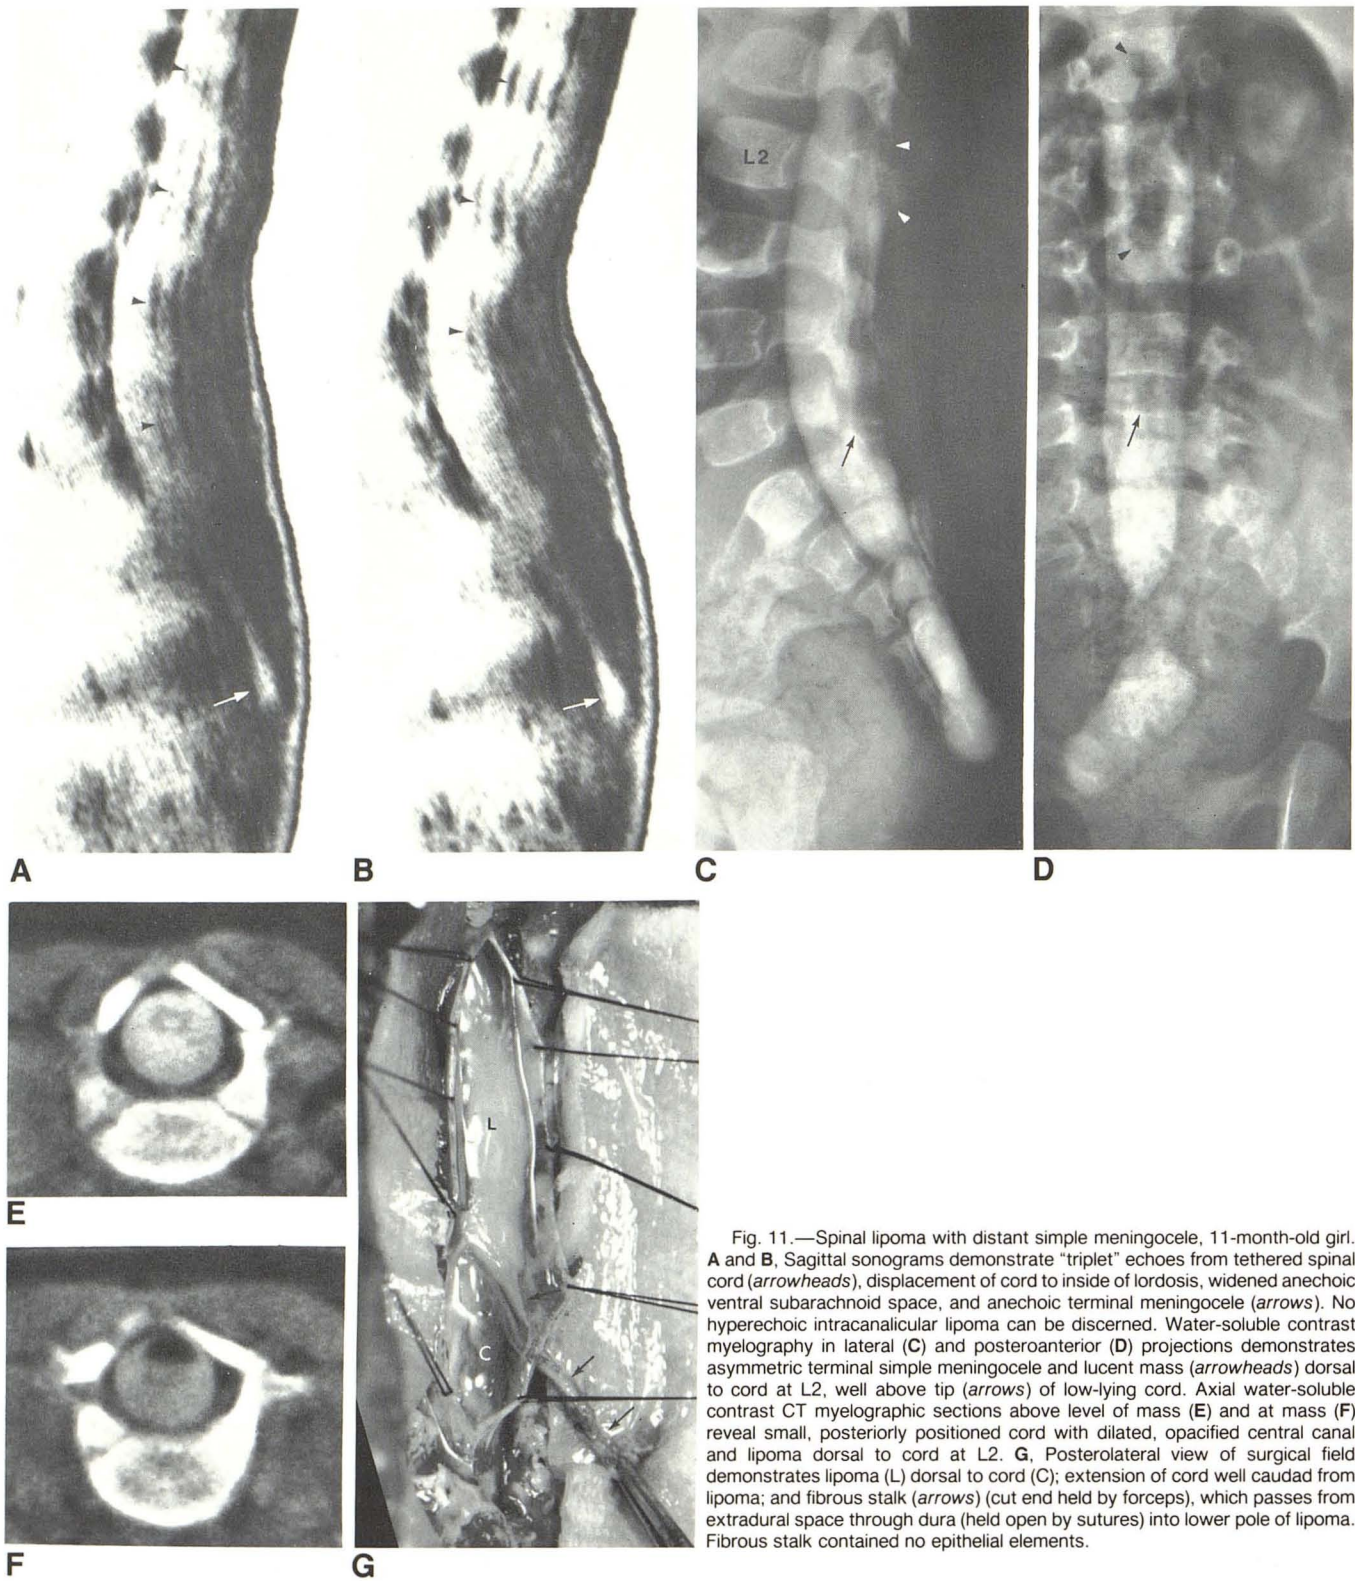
Spinal lipoma with distant simple meningocele, 11-month-old girl. A and B, Sagittal sonograms demonstrate "triplet" echoes from tethered spinal cord (*arrowheads*), displacement of cord to inside of lordosis, widened anechoic ventral subarachnoid space, and anechoic terminal meningocele (*arrows*). No hyperechoic intracanalicular lipoma can be discerned. Water-soluble contrast myelography in lateral (C) and posteroanterior (D) projections demonstrates asymmetric terminal simple meningocele and lucent mass (*arrowheads*) dorsal to cord at L2, well above tip (*arrows*) of low-lying cord. Axial water-soluble contrast CT myelographic sections above level of mass (E) and at mass (F) reveal small, posteriorly positioned cord with dilated, opacified central canal and lipoma dorsal to cord at L2. G, Posterolateral view of surgical field demonstrates lipoma (L) dorsal to cord (C); extension of cord well caudal from lipoma; and fibrous stalk (*arrows*) (cut end held by forceps), which passes from extradural space through dura (held open by sutures) into lower pole of lipoma. Fibrous stalk contained no epithelial elements.
